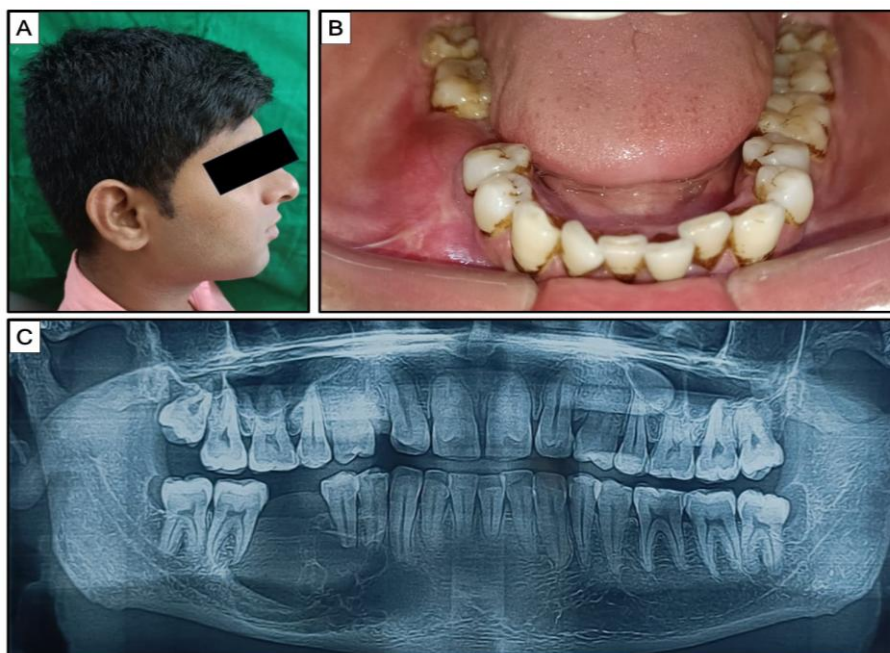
A) Lateral profile view showing extraoral swelling in the lower third of the face; B) Intraoral swelling leading to buccal vestibule obliteration; C) Orthopantomogram showing multilocular radiolucency involving the right mandibular body
